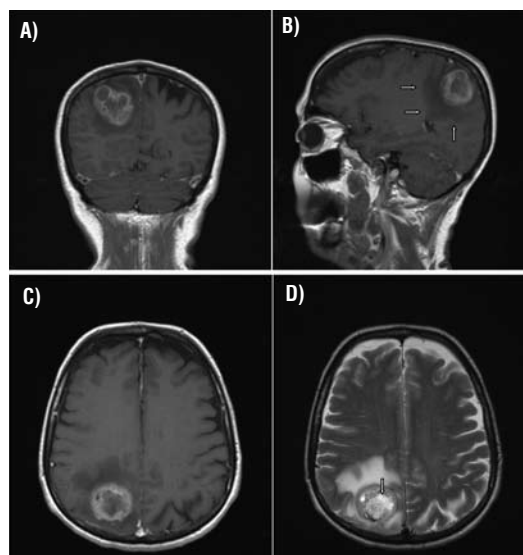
A) Coronal T1-weighted MRI and B) sagittal T1-weighted MR image show right parietal subcortical tumour, size 40x34x33 mm with expressed ring gadolinium imbibitions and deeply spreading oedema (white arrows); C) Axial T1 and D) Axial MRI, T2- weighted image shows extensive peritumoral oedema and bleeding in partly necrotic tumour (white arrow) (Vrabec-Matković D., 2006)
